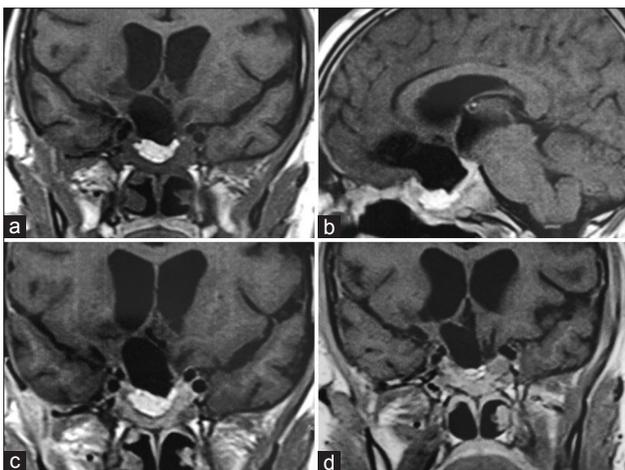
Four-month follow-up axial (a) and sagittal results (b) from T1-weighted magnetic resonance imaging revealed a hyperintense sellar mass, which was compatible with an autologous fat graft that was used to prevent nasal fistula. Findings from T1-weighted gadolinium-enhanced magnetic resonance imaging after 4 months (c) and 18 months (d)
